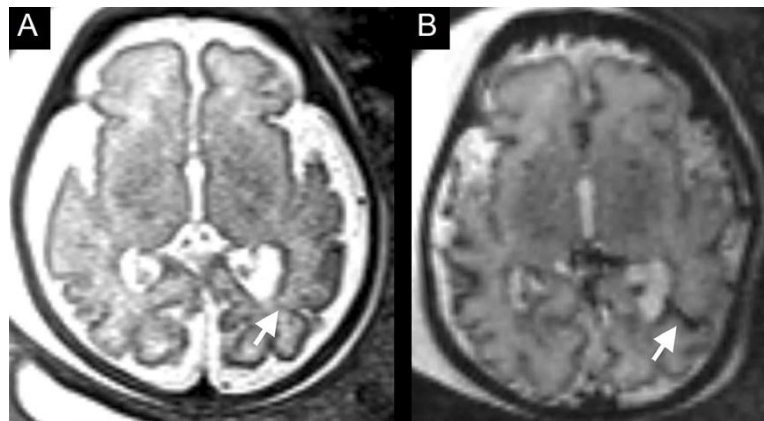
Pre-natal brain MRI of the child at 33 weeks' gestational age. Axial T2 HASTE (A) and T2 gradient echo (B) showing a linear hypointense image in the left parietal region extending from the atrium of the lateral ventricle up to the cortex (*arrows*), compatible with a developmental venous anomaly. Unilateral mild ventriculomegaly is also present.
